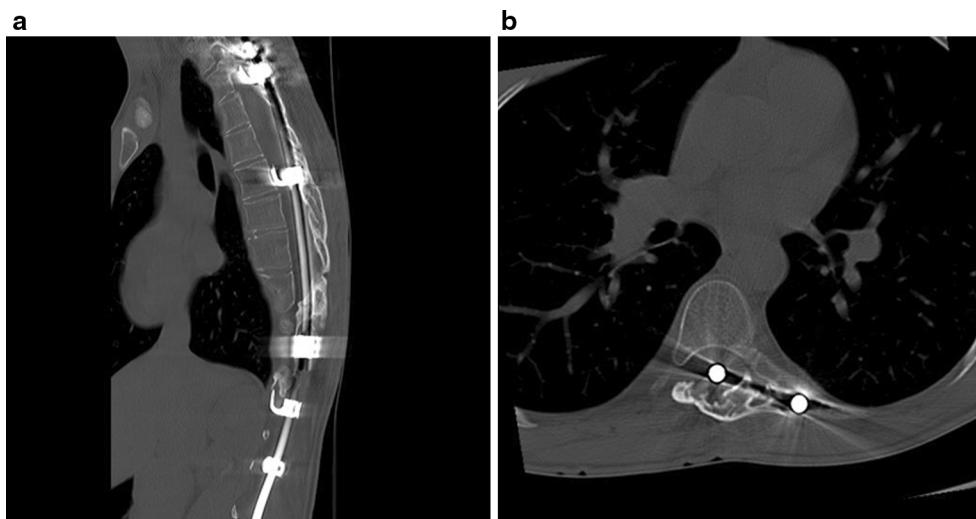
CT: a sagittal reconstruction and b axial section showing the intraspinal migration of the convex rod
